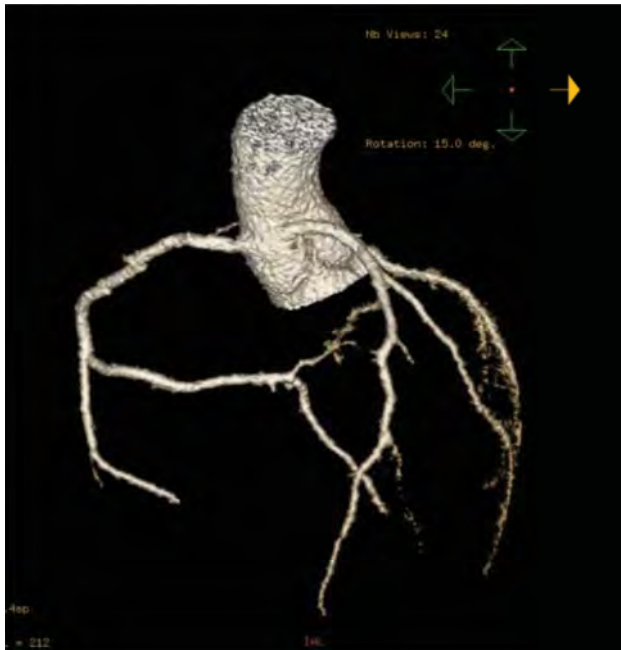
CTA with three-dimensional rendering of anomalous aortic origin of the LCA from the right sinus of Valsalva.
